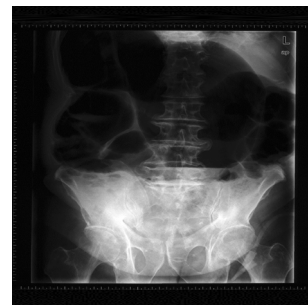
A nasogastric tube was inserted and oral intake was stopped. Two days later, repeated X-ray showed a huge dilatation of the colon
